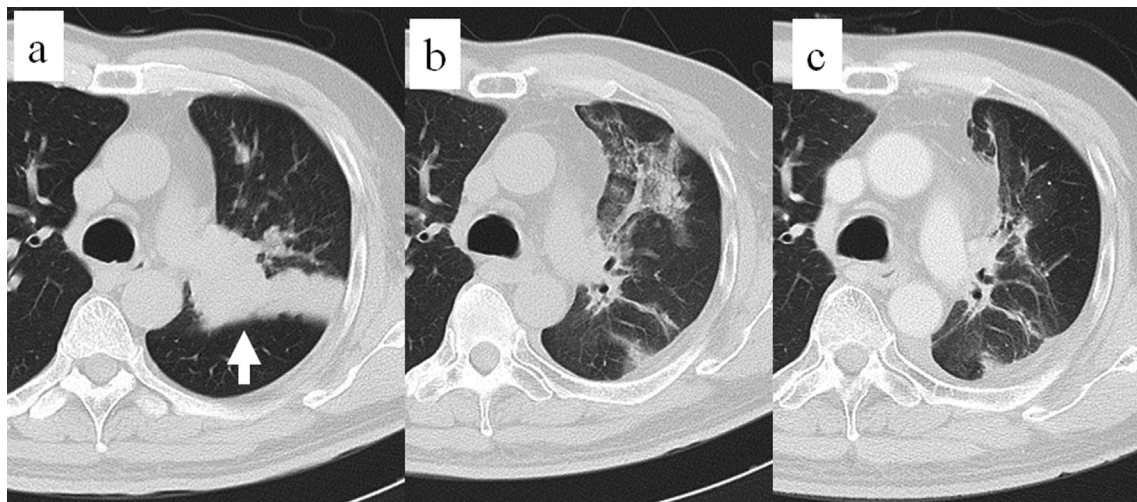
Chest CT in case 2. a) A tumor in the left upper lobe (arrow). b) Preoperative radiation pneumonitis. c) Inflammation of the lungs was improved with only residual fibrosis.
